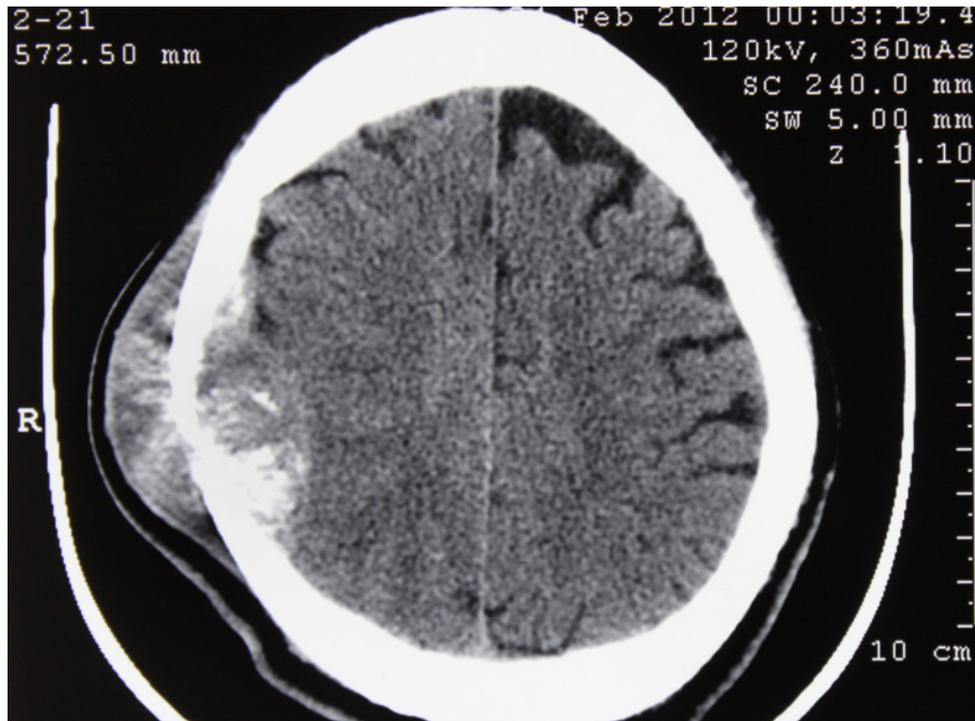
MRI showed a 6.0x4.0 cm mass, extending from bottom of scalp and epidural space.
